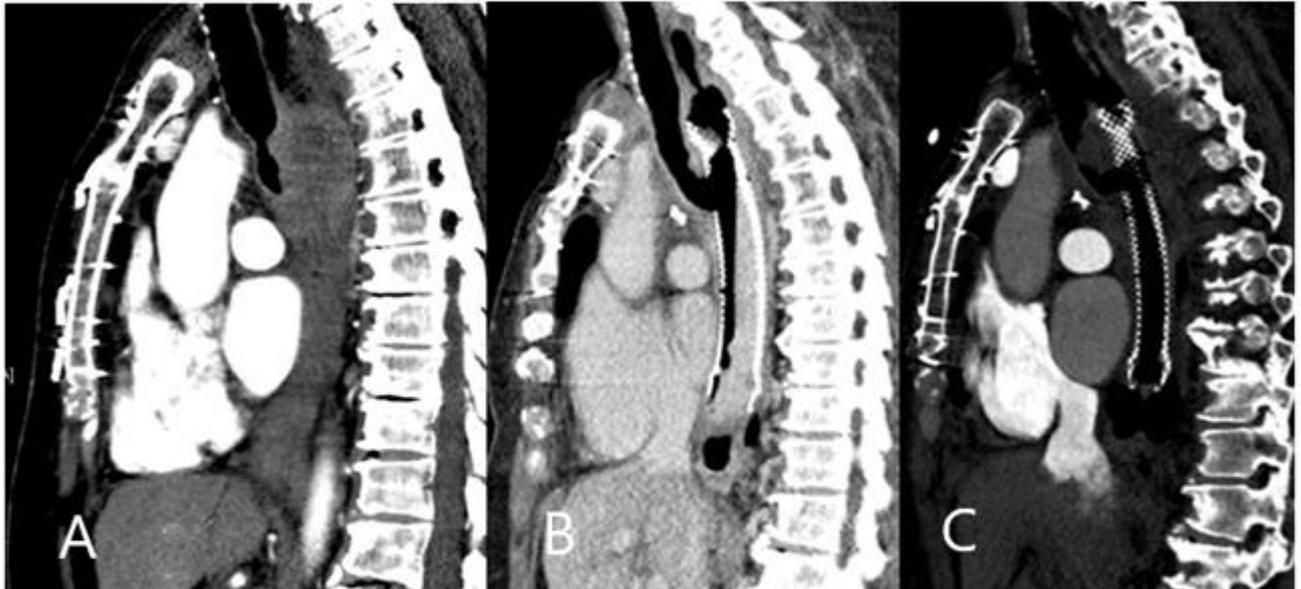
Sagittal CT imaging of fluctuating extent of mediastinal tumour burden. A) CT chest at presentation with oesophageal obstruction secondary to mediastinal disease, on lenvatinib therapy (January 2019) B) CT chest at presentation with tracheo-oesophageal fistula, with interval insertion of oesophageal stent, on dabrafenib and trametinib (February 2019). C) CT pulmonary angiogram at time of respiratory deterioration from tracheal obstruction, off all therapy (March 2019).
